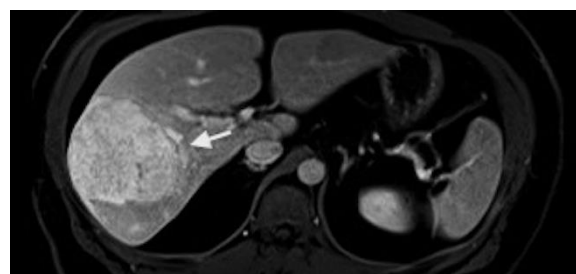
MRI showing a large adenomatous lesion in the right hepatic lobe
